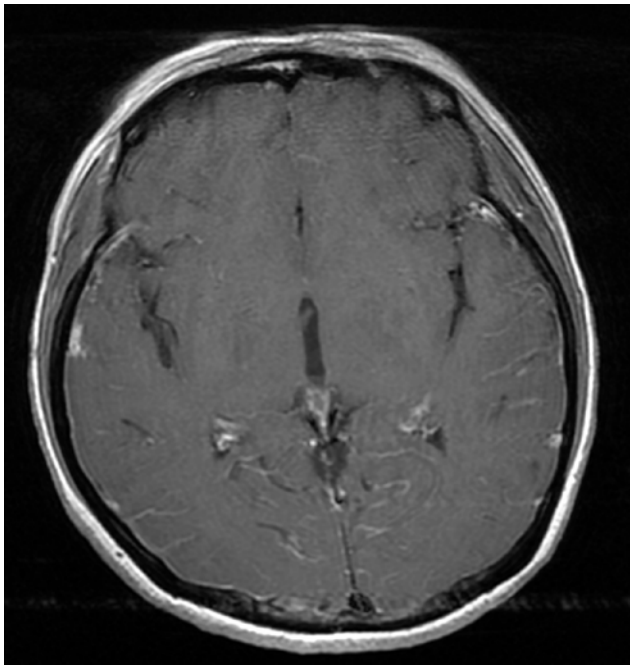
Axial gadolinium-enhanced T1-weighted images show increased leptomeningeal contrast enhancement in both temporal lobes and the right occipital lobe.
